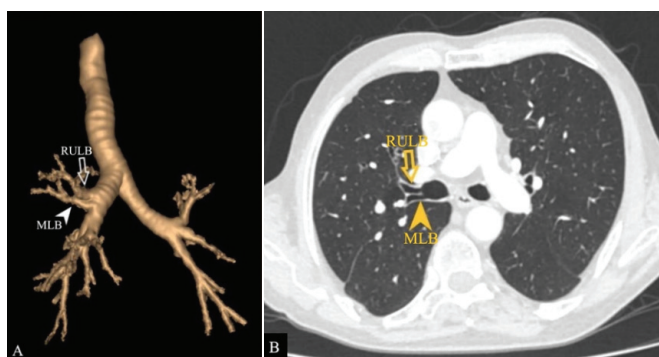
74-year-old male patient, A) 3D reformatted B) axial thorax CT images shows MLB originating just inferior of the RULB
